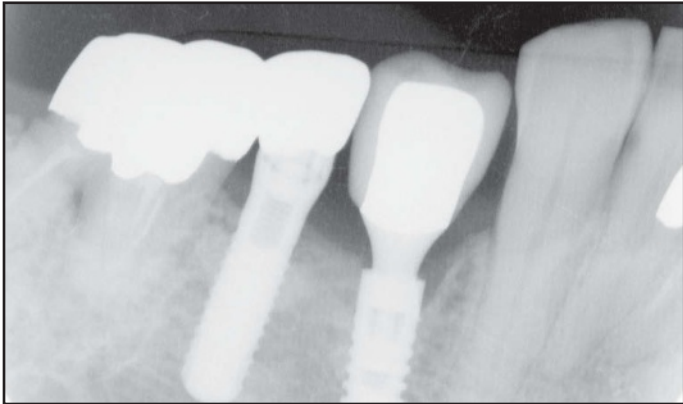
Radiographic findings 1 year after implant placement in Case 2.
